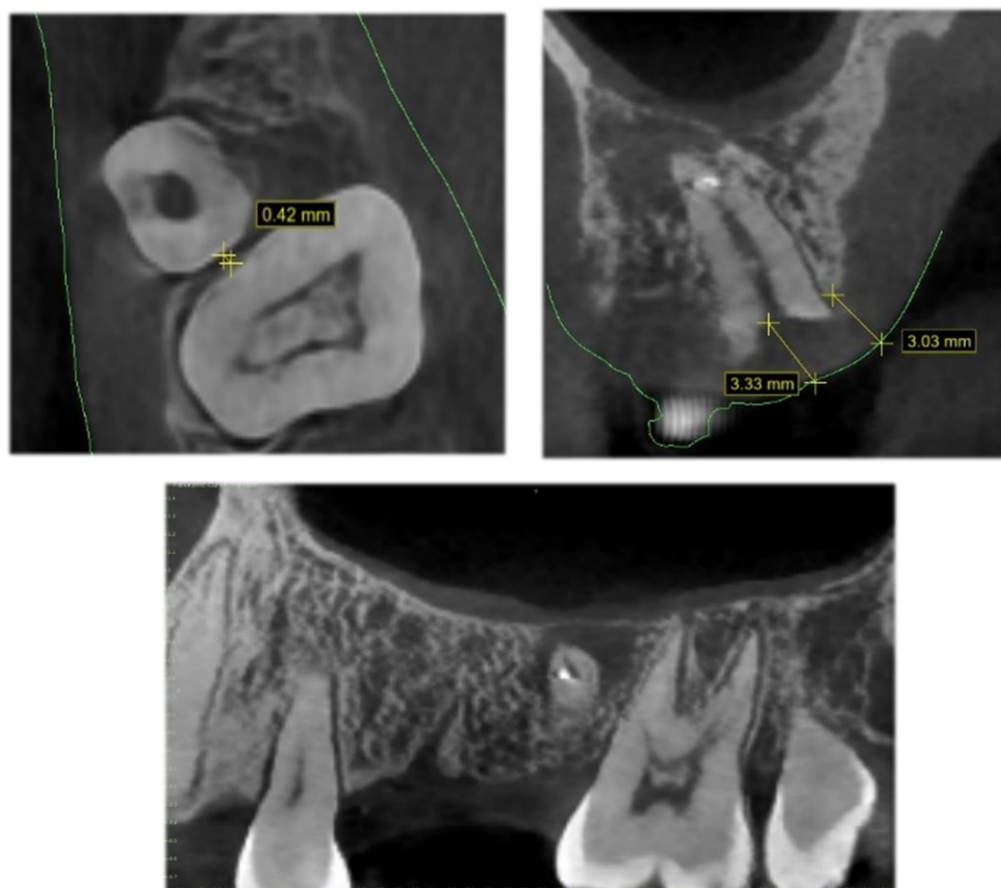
Preoperative CBCT demonstrating proximity of the palatal root fragment to the adjacent second molar and maxillary sinus floor.
